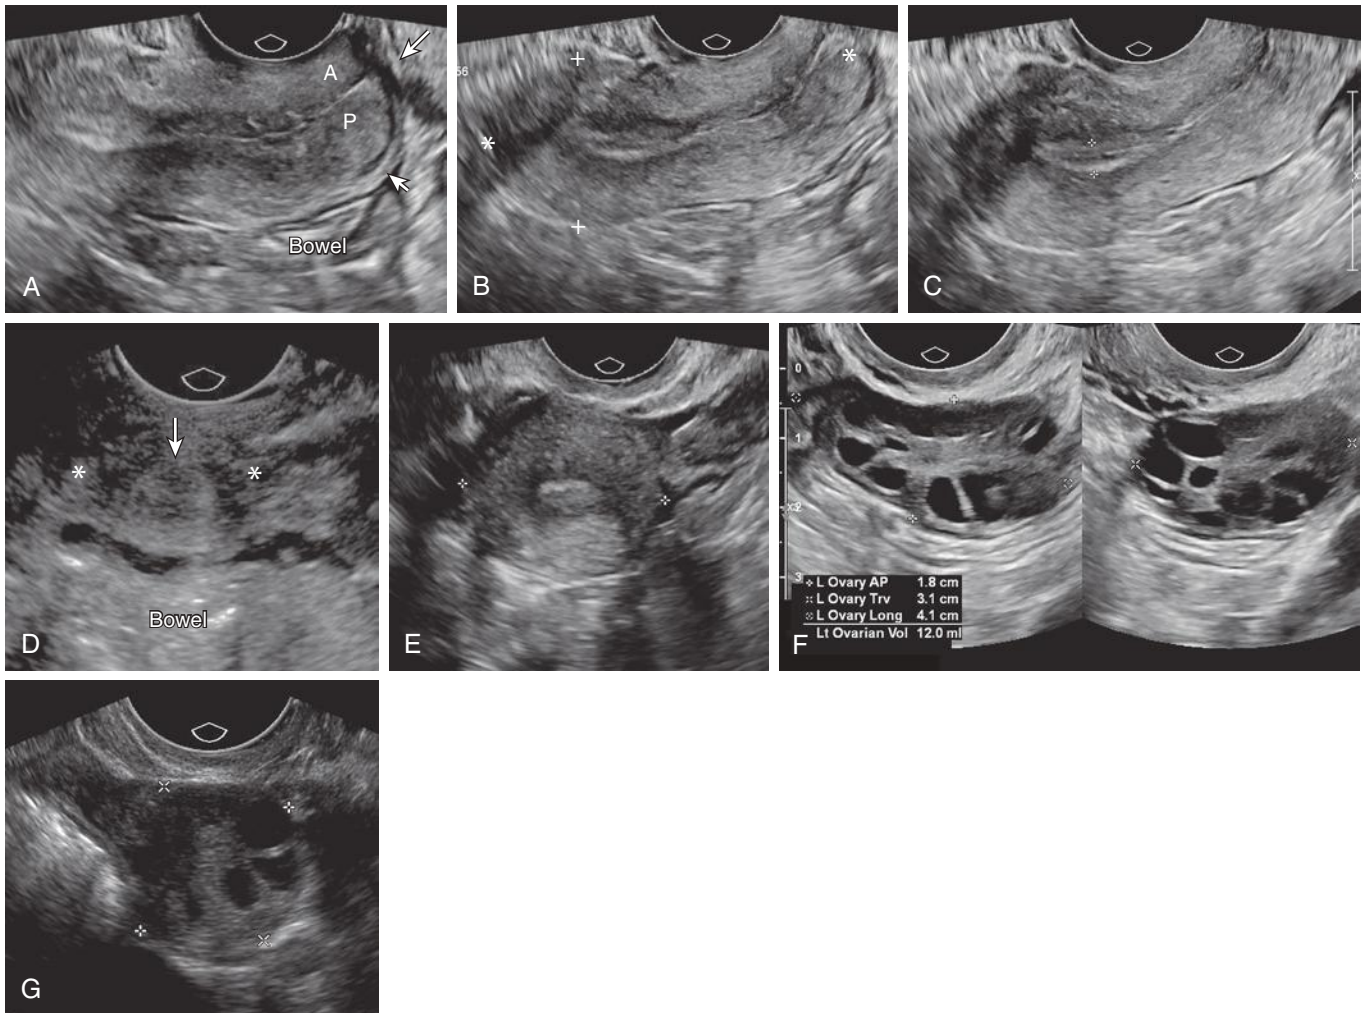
Representative images from a transvaginal sonogram in a single patient. A, Longitudinal axis view of the cervix and posterior cul-de-sac. Bowel loops are noted in the cul-de-sac. A, anterior lip of the cervix; P, posterior lip of the cervix. Long arrow indicates the external os. Short arrow indicates the posterior vaginal fornix. B, Longitudinal axis midline view of the uterus with measurements of uterine size (*calipers*). C, Midline longitudinal axis view of the uterus with measurements of the endometrium (*calipers*). Note that the endometrium is visible throughout the entire length of the uterus and can be seen to be continuous with the endocervical canal. D, Coronal or short-axis view of the cervix. The outer wall of the cervix is marked by the calipers (*asterisks*). Solid arrow indicates the central echogenic endocervical canal, which is surrounded by the hypoechoic fibrous cervical stroma. Note fluid-filled loop of bowel posterior to cervix in the cul-de-sac. E, Coronal or short-axis view of the uterus (*calipers*). Note central echogenic endometrium and surrounding hypoechoic subendometrial halo. F, Sagittal and coronal (short-axis) view of the left ovary (*calipers*). G, Coronal (*short axis*) view of the right ovary (*calipers*) demonstrating numerous small anechoic follicles.
